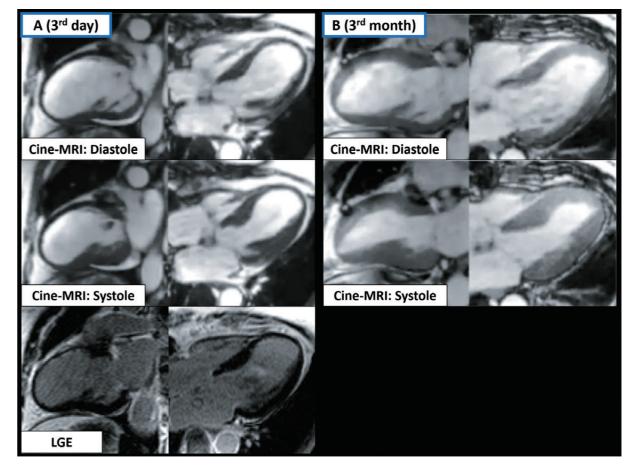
Cardiac MRI performed 3 days and 3 months after a myocardial infarction (MI) in a 68-year-old man with diabetes mellitus. The patient had a proximal left anterior descending coronary (LAD) occlusion treated with a stent during a coronary angiography.
